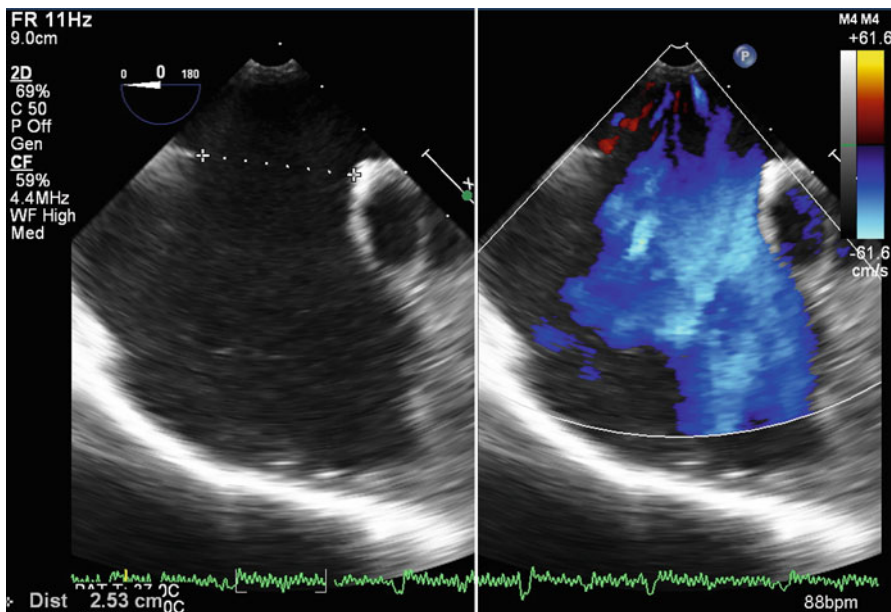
Showing cross-sectional and colour Doppler transoesophageal echocardiographic images of a large atrial septal defect with a deficient aortic rim
